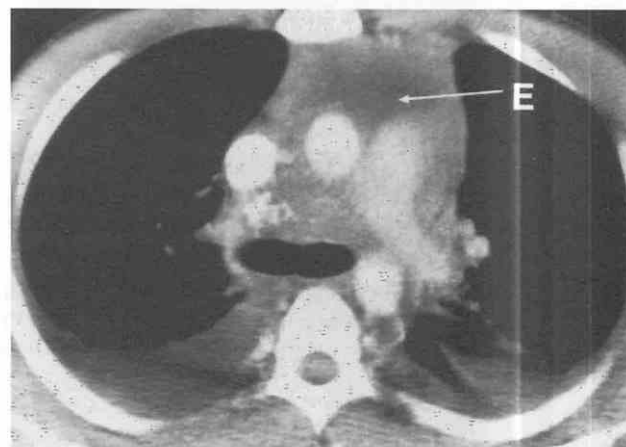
Acute mediastinitis caused by histoplasmosis. CT shows diffuse increased attenuation of mediastinal fat and pericardial effusion (E).
